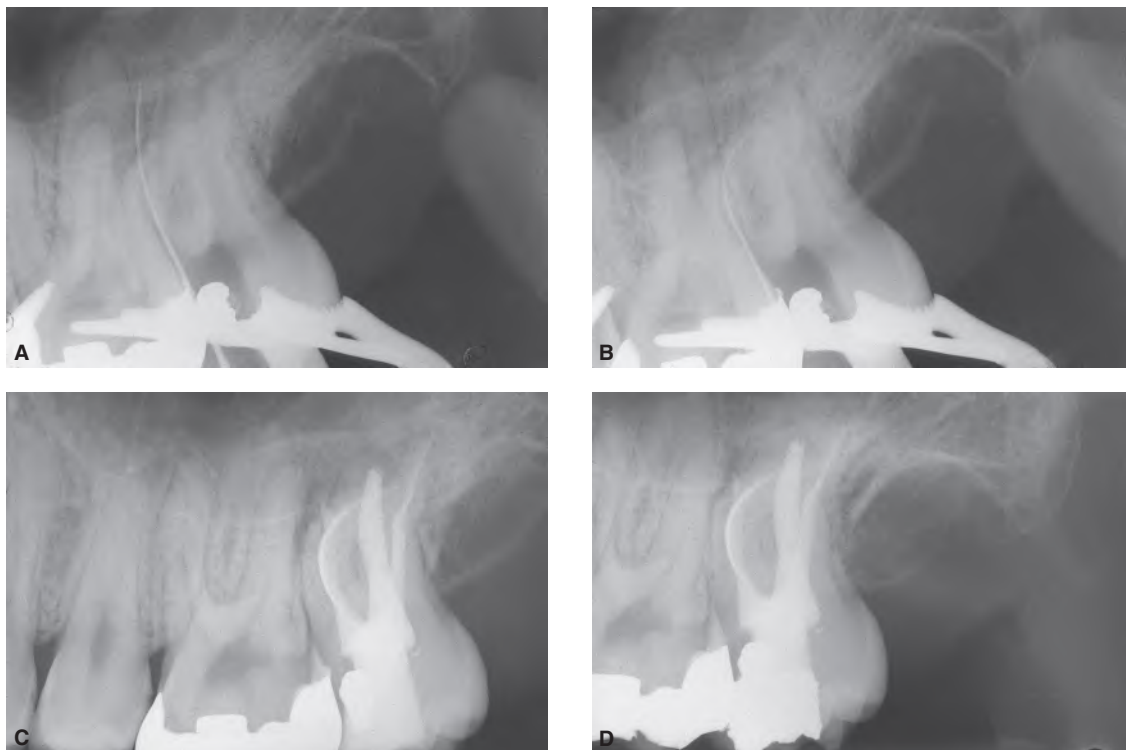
A*. A #20 file demonstrating the presence of a root perforation. *B*. Using a #08 file, the original path of the canal was located. Cleaning and shaping can therefore be completed. *C*. Postoperative radiograph. The perforation was obturated as if it were a lateral canal, using thermoplastic gutta-percha. *D*. One-year follow-up radiograph showing successful results.
